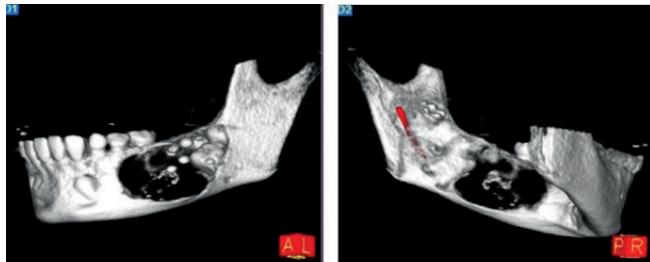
Three-dimensional cone beam computed tomography images revealing unilocular radiolucent lesion with well-defined borders and radiopaque flakes. Perforation of buccal and lingual cortical plates was evident in relation to 74, 75, and unerupted 34, 35, and 36.
